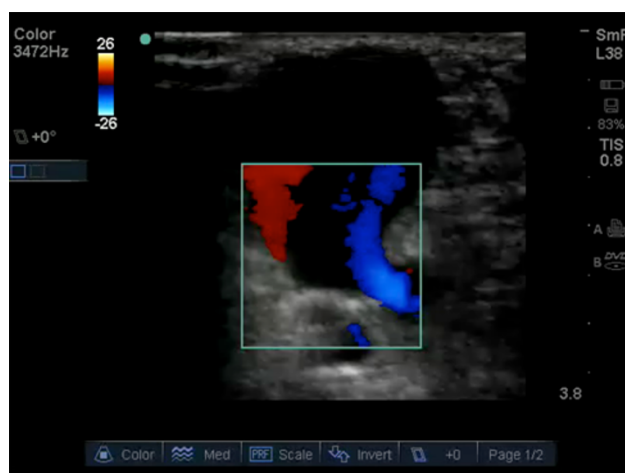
Video clip of color doppler imaging
